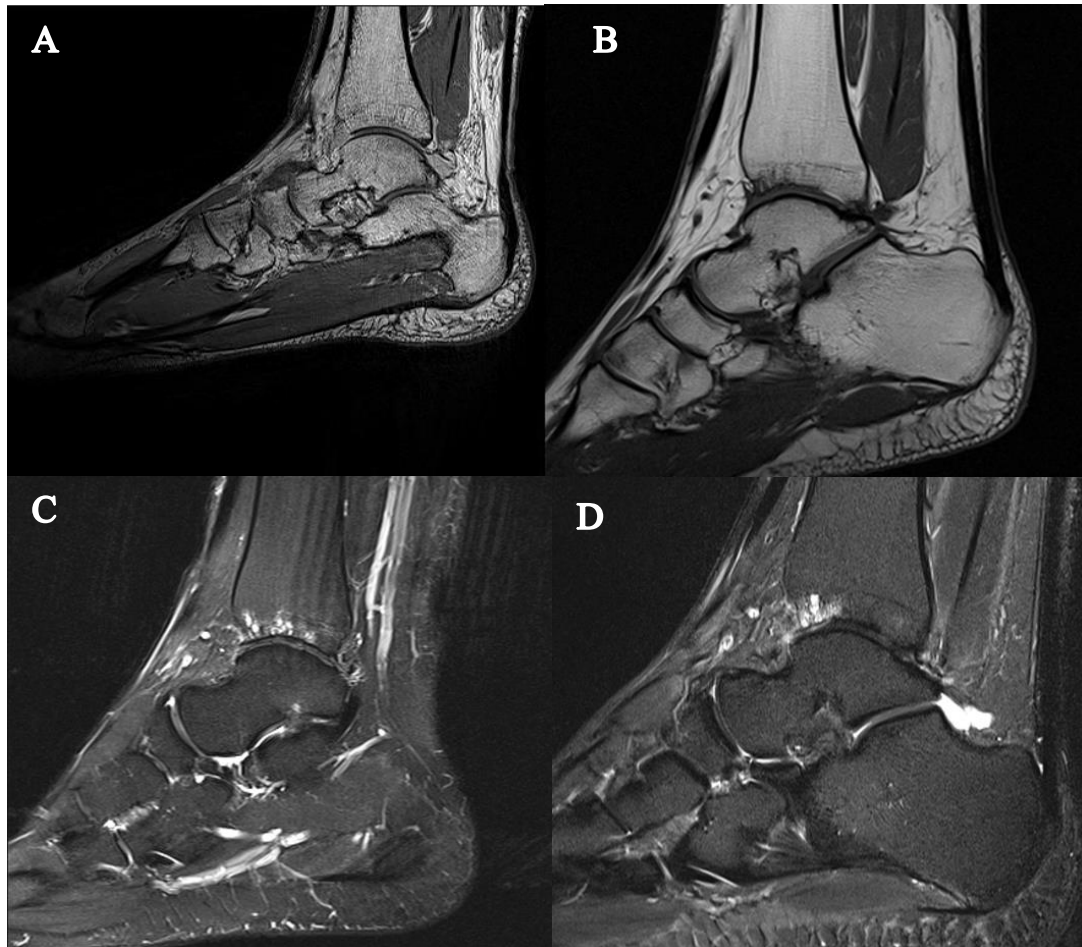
Visualisation of differences in MRI sequences on ankles (A) SPACE, (B) T1 weighted, (C) T2 weighted, (D) STIR
